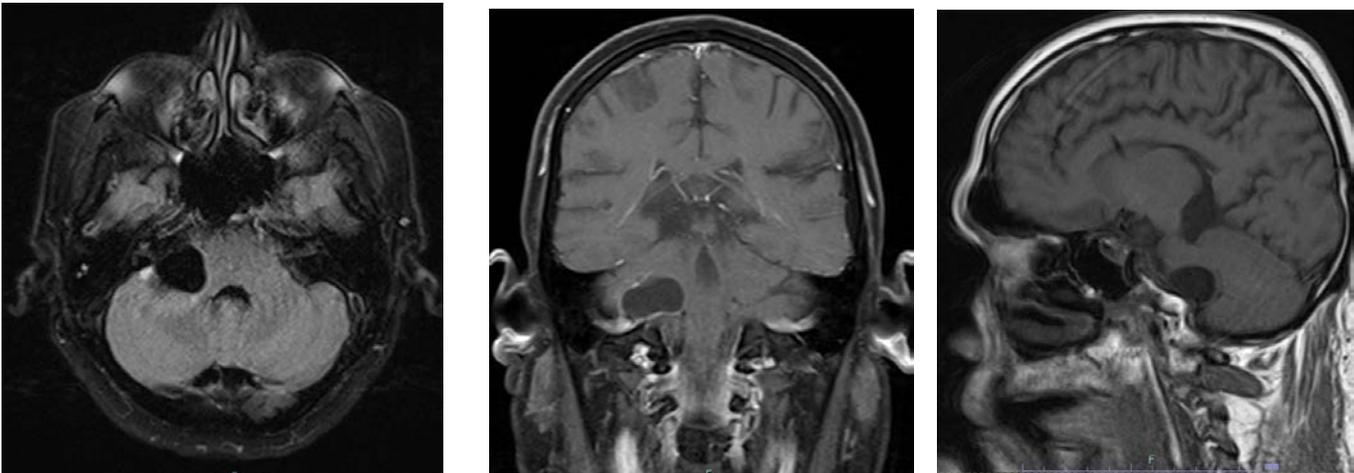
Axial, coronal, sagittal T1-weighted magnetic resonance imaging demonstrating a lesion involving the right cerebellopontine angle cistern extending into the right premedullary cistern with thin rim enhancement and surrounding FLAIR hyperintensity in the right cerebellum with mass effect on the right 7th and 8th cranial nerve and right anterior medulla.
